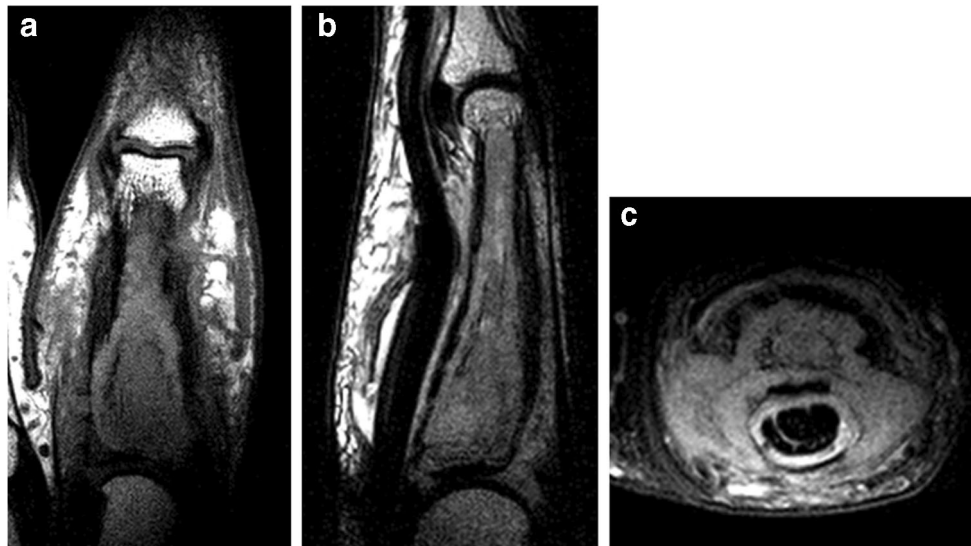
(a) Coronal T1W TSE, (b) sagittal STIR, and (c) axial SPAIR MR images
